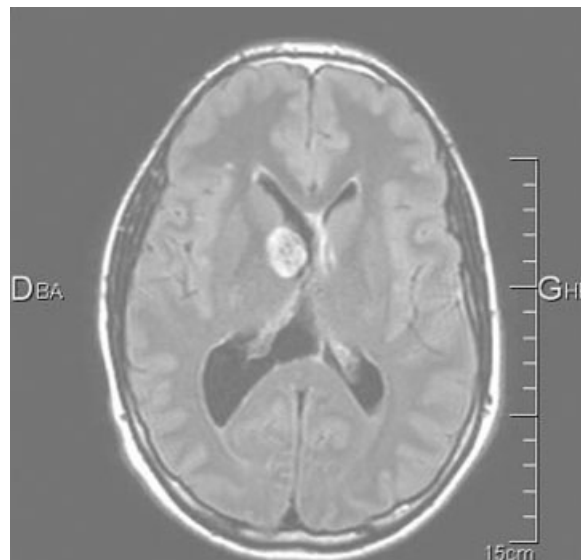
(We-395). MRI showed that the lesion measuring 21×15 mm involved the right lateral ventricle, the head of the right caudate nucleus and a portion of adjacent white matter.
